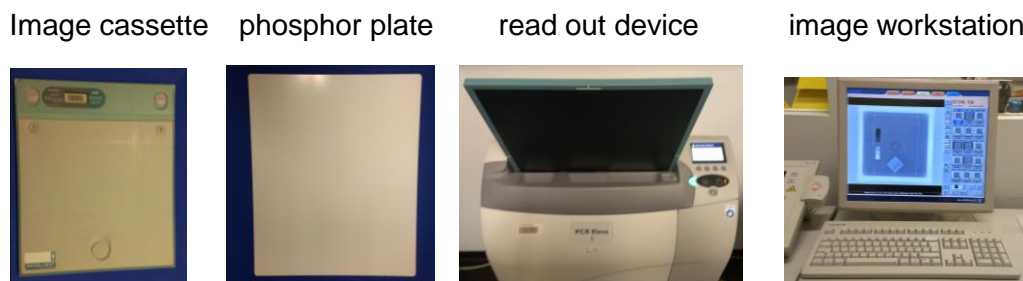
Computed radiography imaging components
